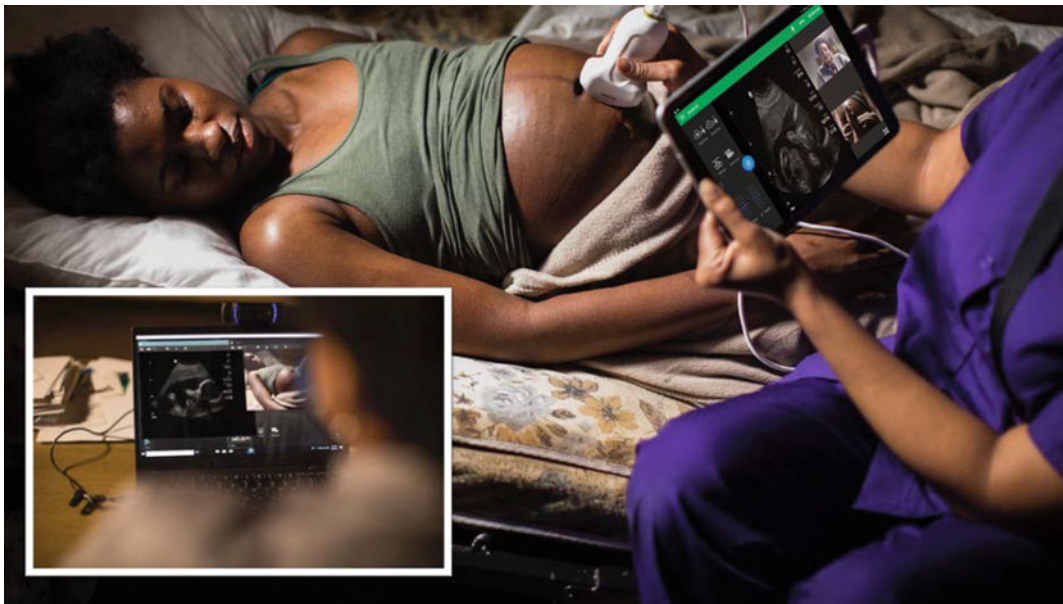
Midwives at rural health clinics in Kenya can now conduct basic ultrasound exams on pregnant women and share data remotely for global virtual collaboration, using Philips Lumify powered by Reacts
